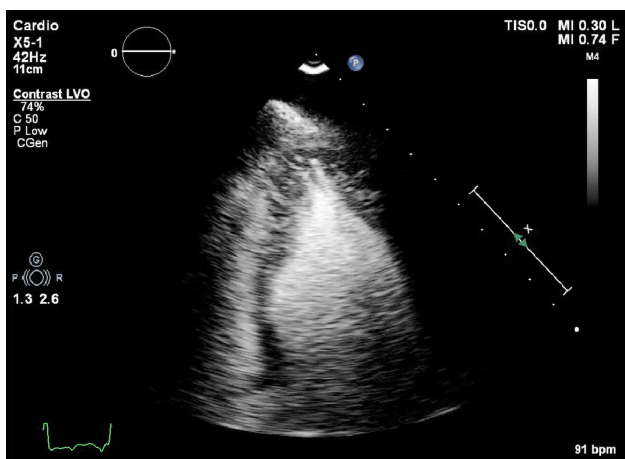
Hypertrophic cardiomyopathy patient with very poor image in apical 4-chambers view. (A,B) Native images, end-diastole (A) and end-systole (B). The endocardium of the lateral wall is not visible, and the apex cannot be seen. (C,D) Contrast-enhanced images, in the same moments in the cardiac cycle. The LV contour is clearly delineated, during systole there is complete cavity obliteration, with an apical aneurysm (arrow). Source: personal collection.
